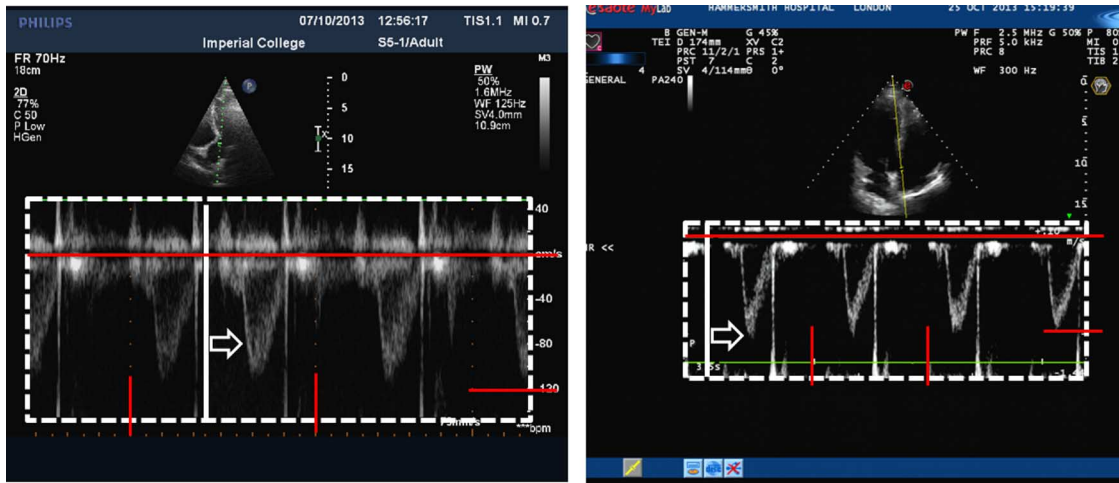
Collection of snapshots of still-frames and automated extraction of Doppler-region, zero-velocity axis, scaling ratios, and updating sliding bar for Philips (left) and Esaote (right) ultrasound scanners.
